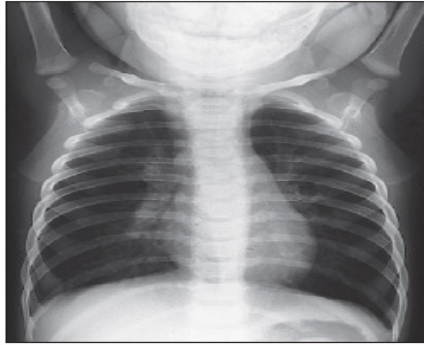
In acute bronchiolitis, the chest X-ray shows hyperinflation of the lungs with flattening of the diaphragm, horizontal ribs and increased hilar bronchial markings. However, chest X-ray is rarely helpful in bronchiolitis.
